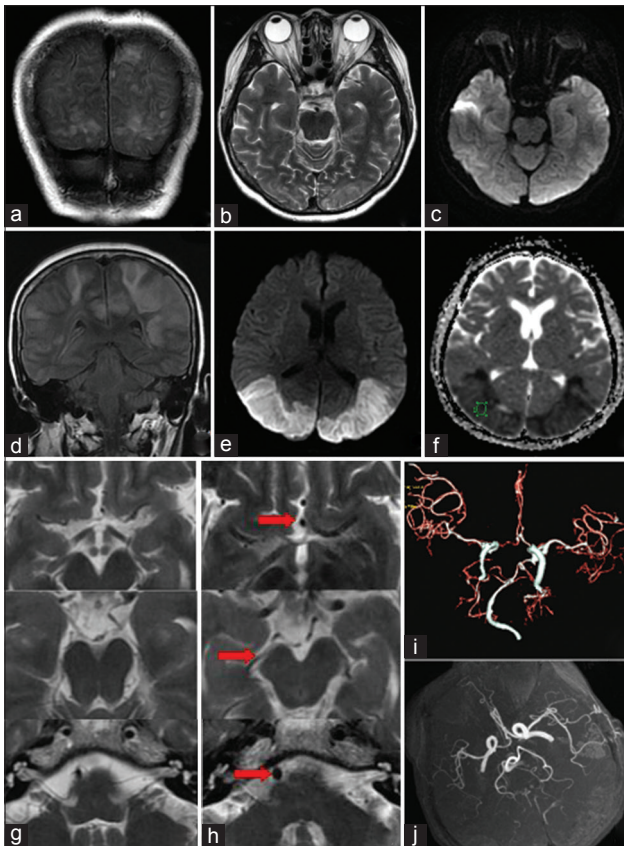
Brain MRI on day 6 after admission demonstrated asymmetric vasogenic edema in bilateral occipital lobes (a-c). On day 11, a repeated MRI showed infarction in bilateral parieto-occipital lobes (d-f). Based on the comparison between axial MR scans at baseline and at 3-month follow-up, blood vessel diameter of cerebral arteries obviously dilated (red arrows) including bilateral anterior cerebral arteries, bilateral posterior cerebral arteries, and basilar artery (g and h). On day 11 after admission, CTA demonstrated diffuse vasoconstriction of intracranial vessels (i). After a 3-month follow-up, MRA showed resolution of the narrowing cerebral arteries (j). MR: Magnetic resonance; MRI: MR imaging; MRA: MR angiography; CTA: Computed tomography angiography.
